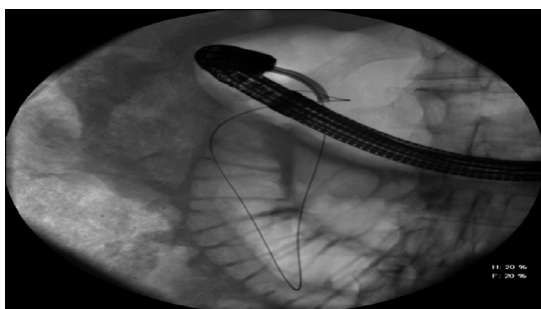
Radiographic view of the choledochoscope (advanced through the therapeutic gastroscope) crossing the duodenal stenosis and allowing passage of the guidewire.
